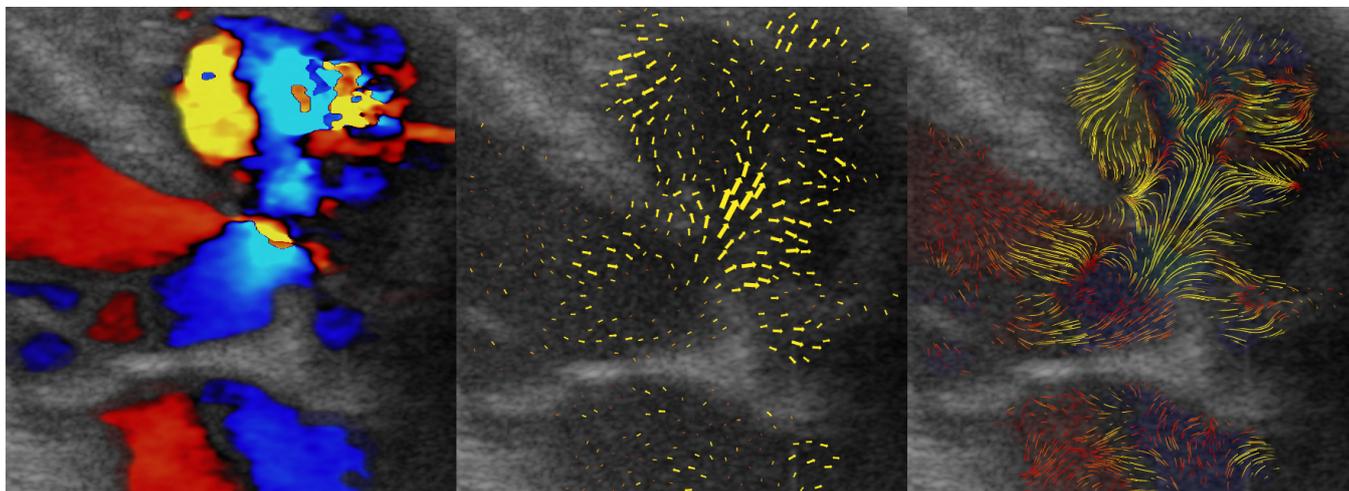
An instant of the systolic phase in a neonate with a perimembranous ventricular septal defect, visualized using color Doppler (left), arrow plot (center), and pathlets (right). The pathlets-based visualization is more effective during playback, and it can also better convey complex flow structures such as the shunt jet through the septum and the vortices in the right ventricle on the top right of the image.
